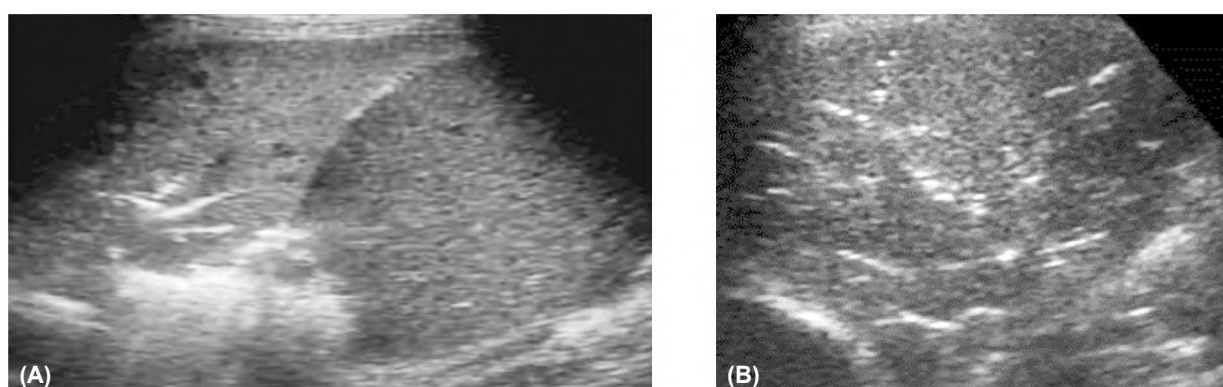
Pneumonia in a 20-year-old male with fever and cough. Ultrasound showing consolidation with air bronchogram.
